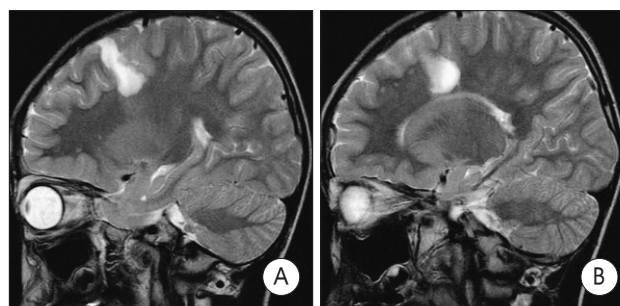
In terms of surgical standpoint for determination of extent of resection, corticectomy based on ictal single photon emission computed tomography and ultrasound-guided lesionectomy of periventricular calcified lesion are performed (A, B).
